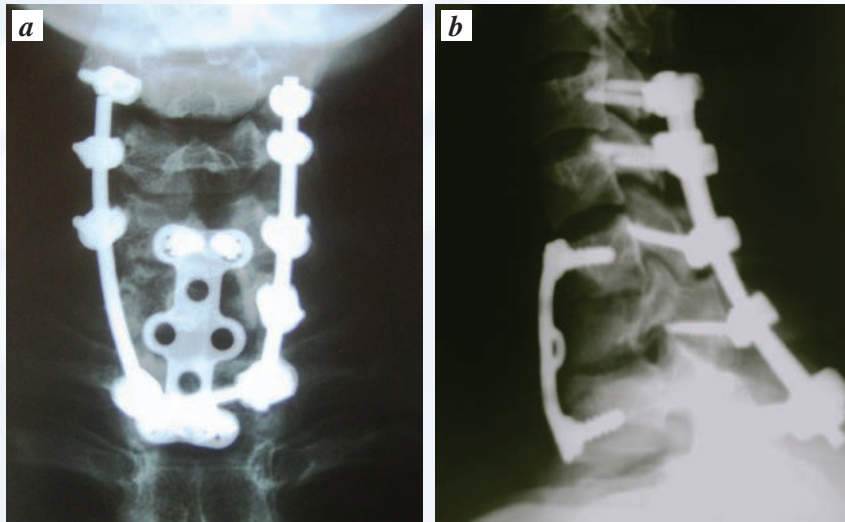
X-ray of the cervical spine: a – anterior-posterior projection; b – lateral projection.
